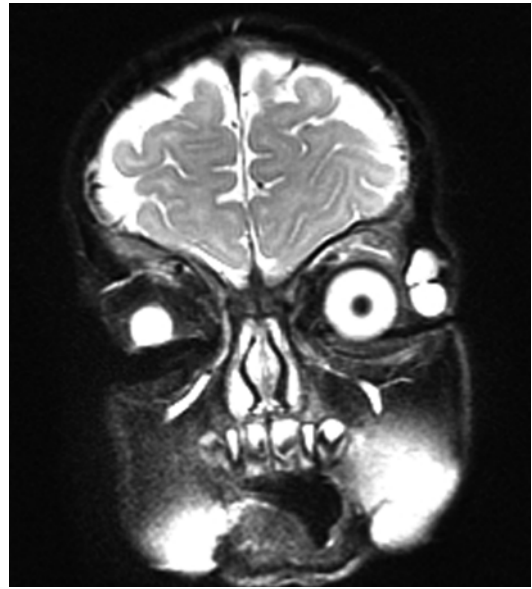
MRI dermoid cyst: T2-weighted MR image showing a dumbbell-shaped lesion at the frontozygomatic fissure (Dr. Robert M. Verdijk)
